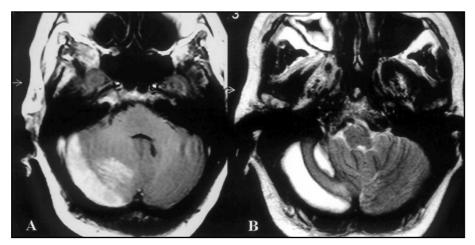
Axial MRI, T1 weighted (A) and T2 weighted (B) showing the extra-axial collection associated with an intraparenchymal hemorrhage in the right cerebellar hemisphere.
